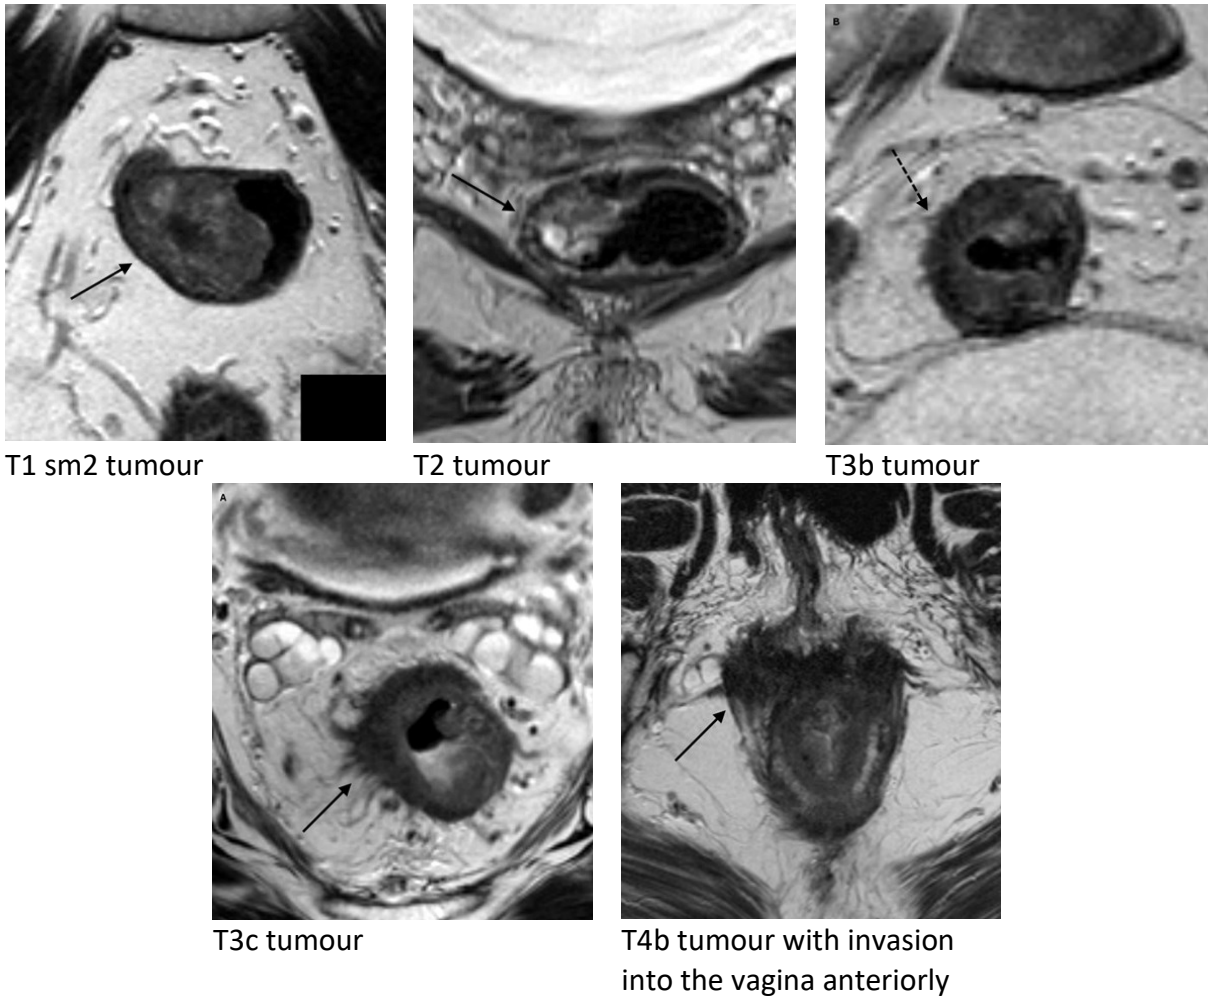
High-resolution axial T2-weighted MRI scans of T1, T2, T3b, T3c and T4 tumours.
